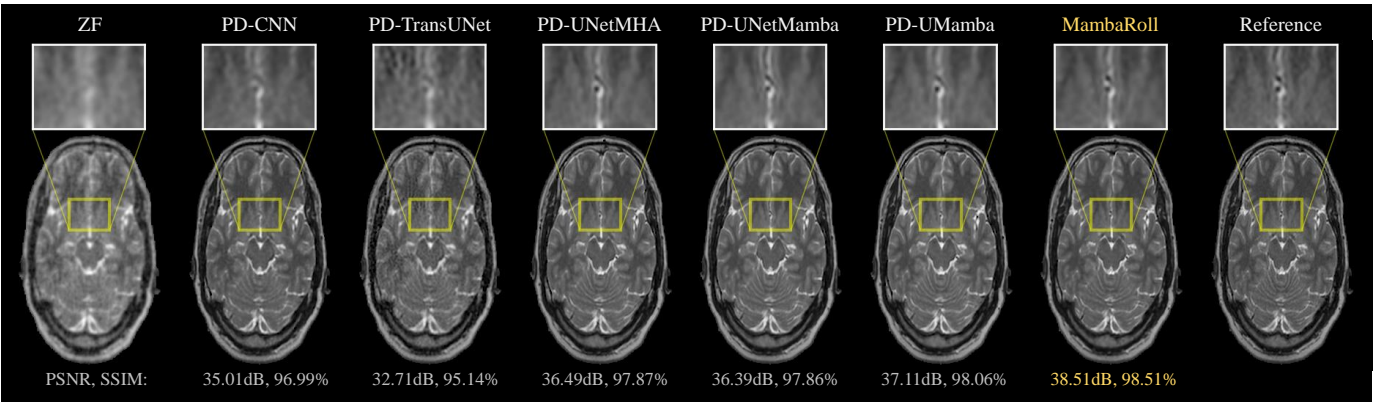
Accelerated MRI reconstructions of a representative cross-section from a T_2 -weighted acquisition in IXI at $R = 8$. Reconstructed images from competing methods are shown along with a linear reconstruction of undersampled data (ZF), and the reference image derived from fully-sampled data. Zoom-in windows are included to highlight regions where methods show differences in tissue depiction.
